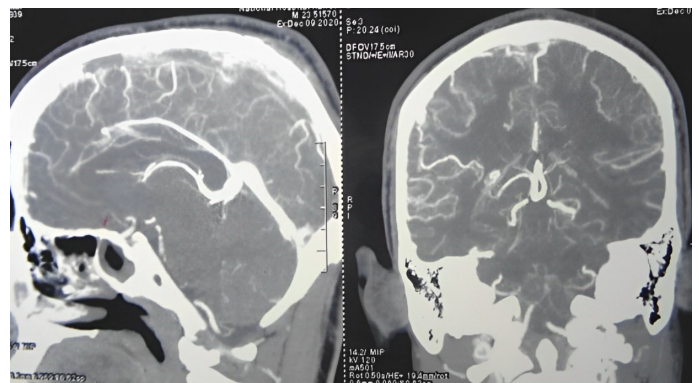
CT venogram of cerebral veins, sagittal view (left panel), and coronal view (right panel), depicting extensive filling defects in the superior sagittal sinus.
